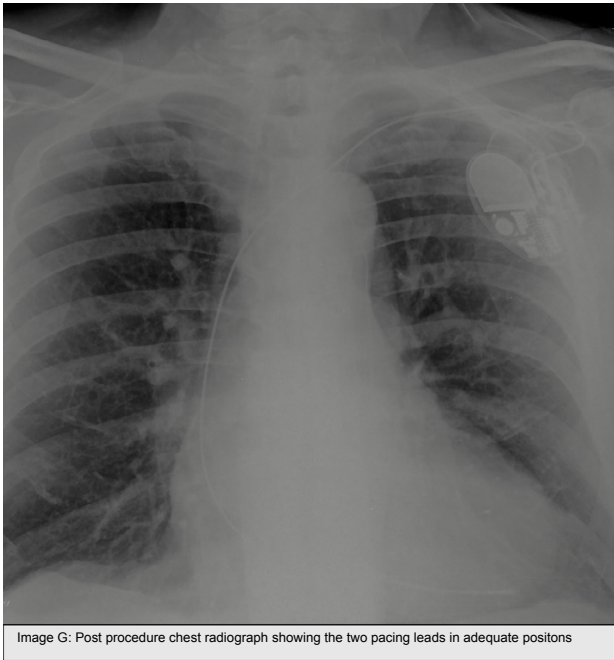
Post procedure chest radiograph showing the two pacing leads in adequate positions.
